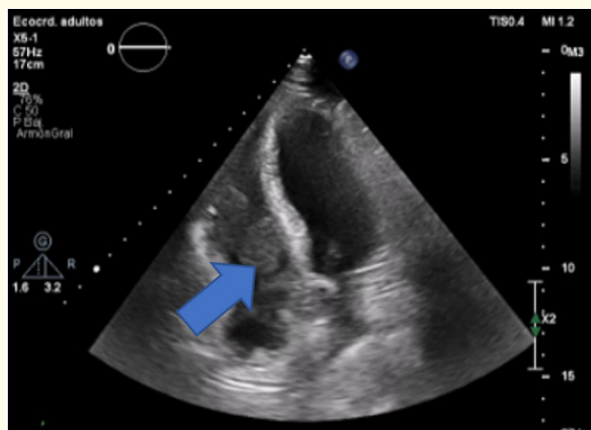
Transthoracic echocardiogram showing a mass in the right atrium. 4.4x1.9 cm at the level of the tricuspid ring oscillates between the RA / and the RV obstructing the tricuspid valve. (arrow).
